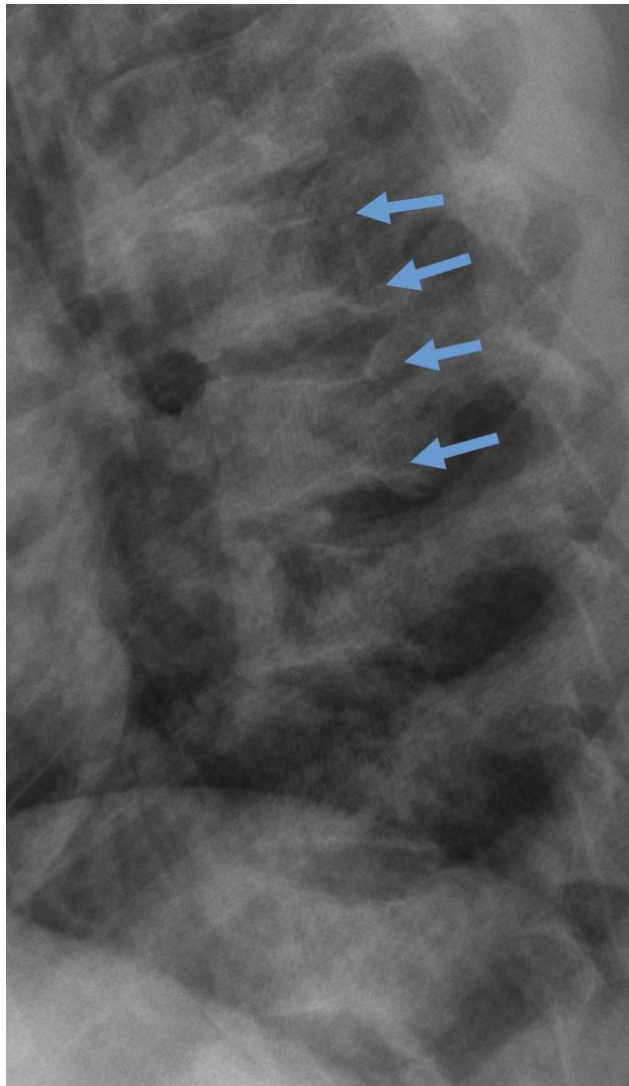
Lateral thoracic spine X-ray (coned view) highlights the changes involving the vertebral body end plates (arrows).
